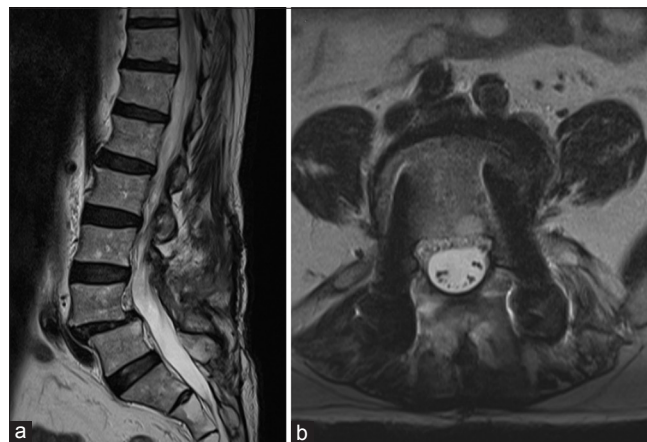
Sagittal T2-weighted (a) and axial T2-weighted (b) MRI of the lumbar spine showing the spinal canal decompression with resolution of the pseudomeningocele
